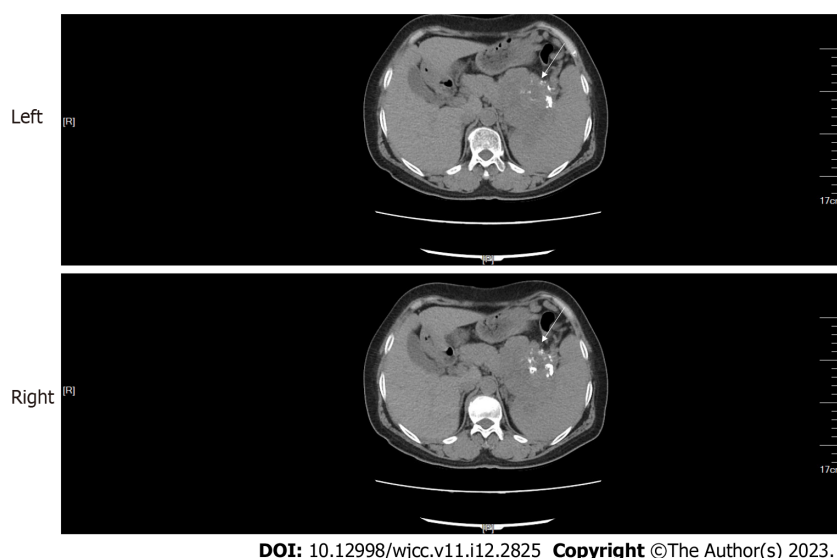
Abdominal computed tomography. A mass (arrow) with multiple calcifications between the pancreas and the spleen was observed. The boundary between the mass and the pancreas and spleen was poorly defined.
